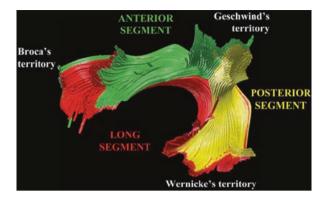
MRI-based tractographic reconstruction of the arcuate fasciculus. Frontal and temporoparietal areas are connected through direct and indirect pathways. The direct pathway (long segment shown in *red*) runs medially and corresponds to classical descriptions of the arcuate fasciculus. The indirect pathway runs laterally and is composed of an anterior segment (*green*) connecting the inferior parietal cortex (Geschwind's territory) and Broca's territory and a posterior segment (*yellow*) connecting Geschwind's and Wernicke's territories (Figure from Catani (2005) [107])
